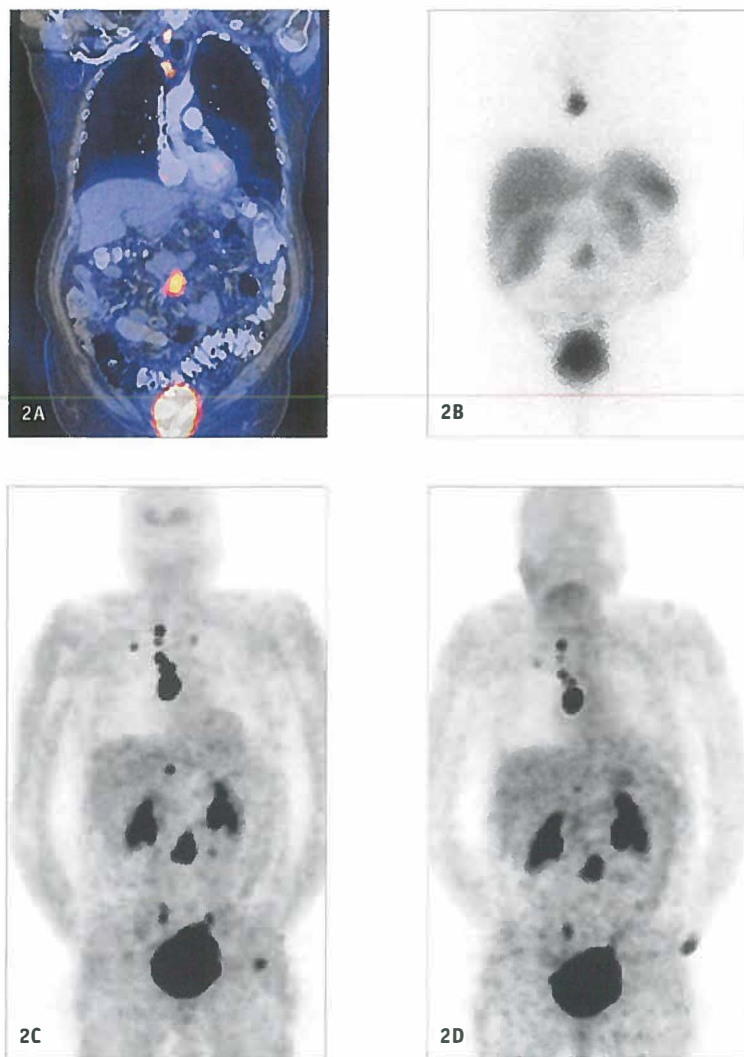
Fused ^{18}F -DOPA – PET CT scan (A), SRS (B), ^{18}F -DOPA PET (C) and ^{11}C -5-HTP PET (D) of a 80 year old male patient with metastatic carcinoid tumour.
